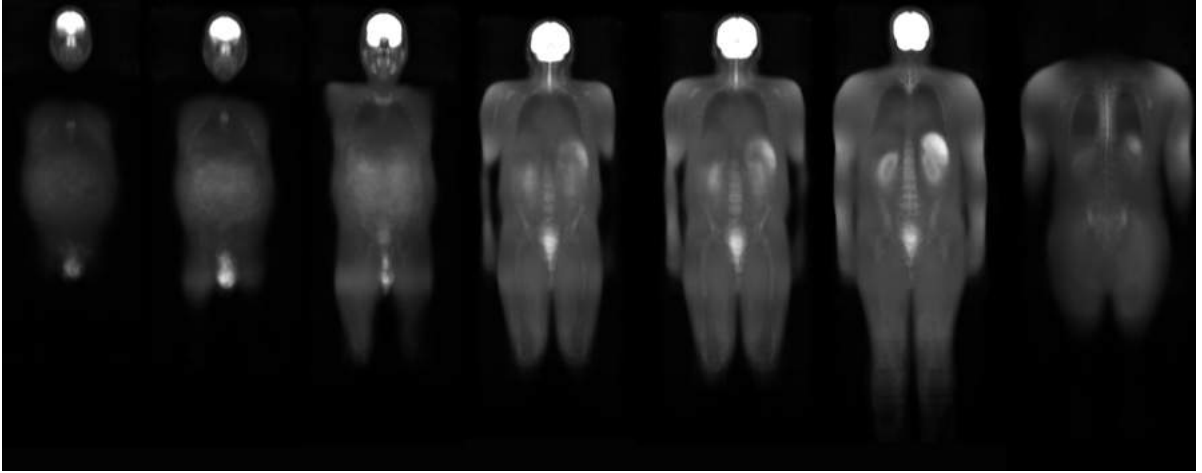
Final male atlas, built with 42 DWI male images. These seven coronal representative slices show that the normal hyperintense organs achieved good alignments, using a mean image as the fixed image.
